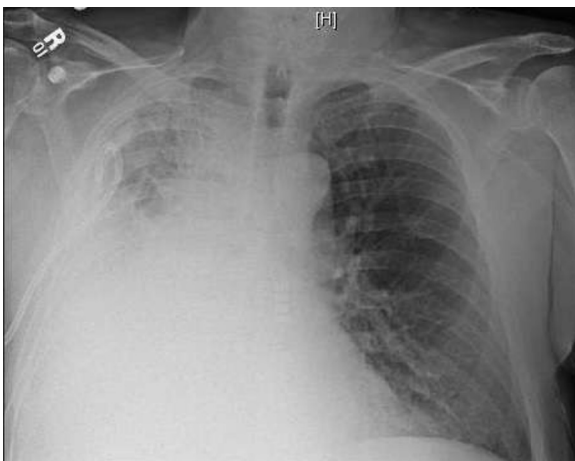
Chest radiograph. Note the right hemithorax opacification without tracheal deviation.
